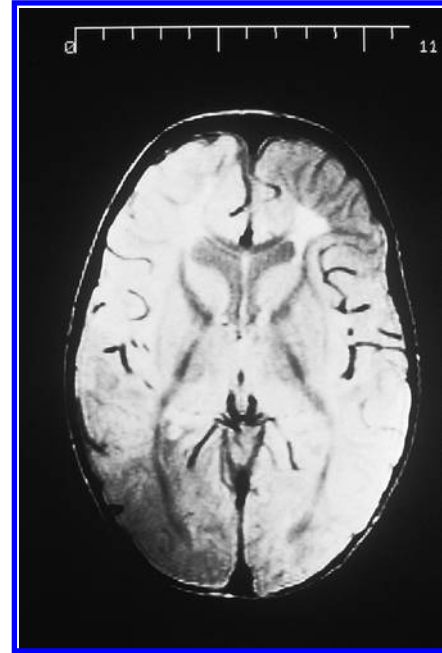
Magnetic resonance imaging of the brain of the patient in Figures 45.4 and 45.5 at 2.5 years reveals increased signal intensity in the frontal white matter. (Reprinted with permission from the *Journal of Inherited Metabolic Disease* [8], with kind permission of Springer Science & Business Media.)
